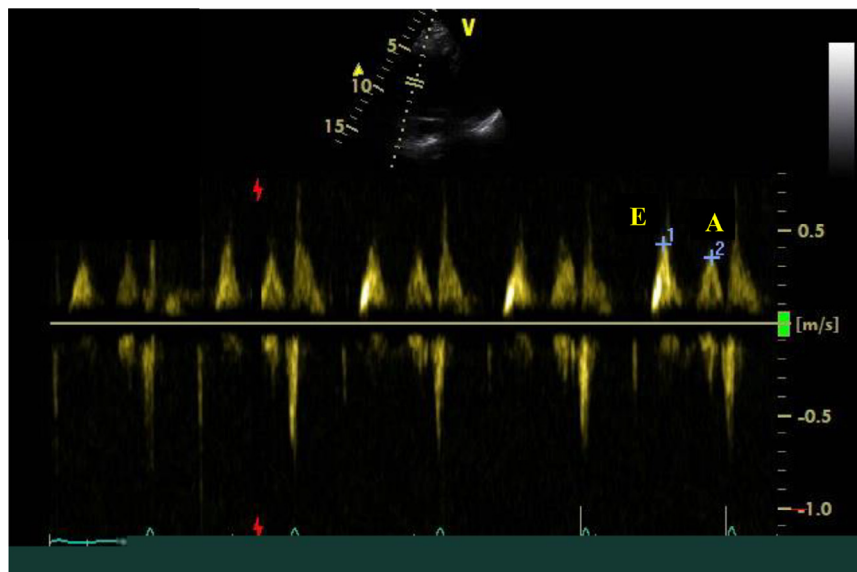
Trans-tricuspid flow delineated with pulse wave Doppler presenting E and A waves.
